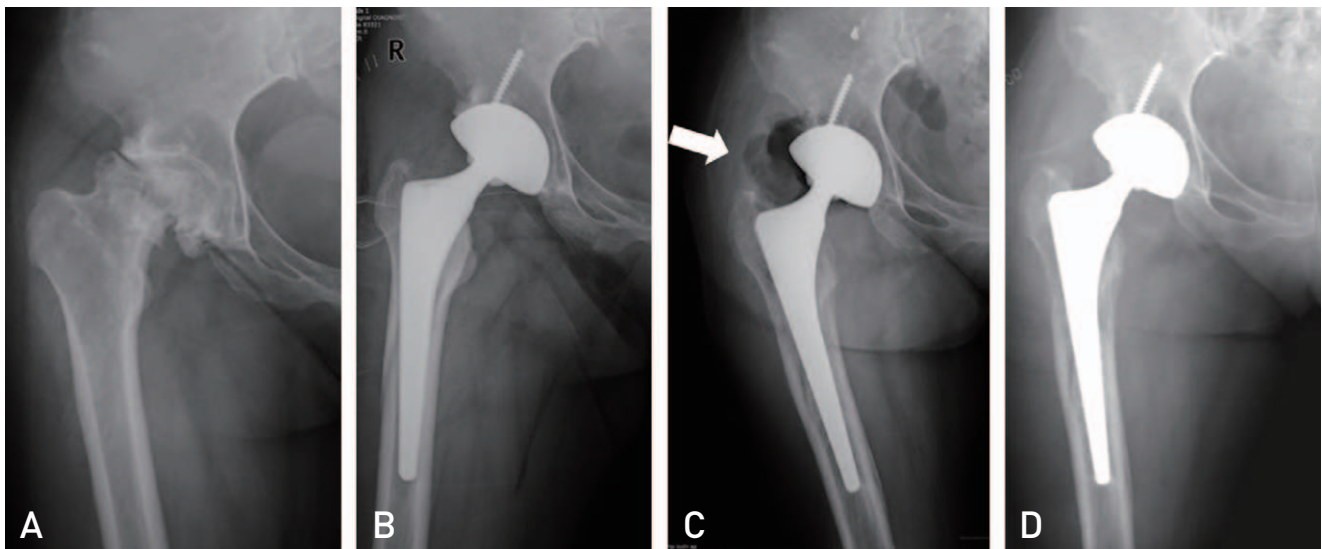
Radiographic images. (A) Anteroposterior radiograph of the pelvis of a 43-year-old female with severe aplastic anemia, showing osteonecrosis of the femoral head and consequent joint destruction. (B) An immediate postoperative radiograph showing total hip arthroplasty with good positioning of the prosthesis. (C) The patient visited the emergency room due to acute onset severe right hip pain, and a follow-up radiograph showed an extensive gas formation around acetabular and femoral components (arrow). (D) A postoperative radiograph after debridement and irrigation. Removal of prosthesis was not performed due to the deteriorated hematologic status of the patient.
